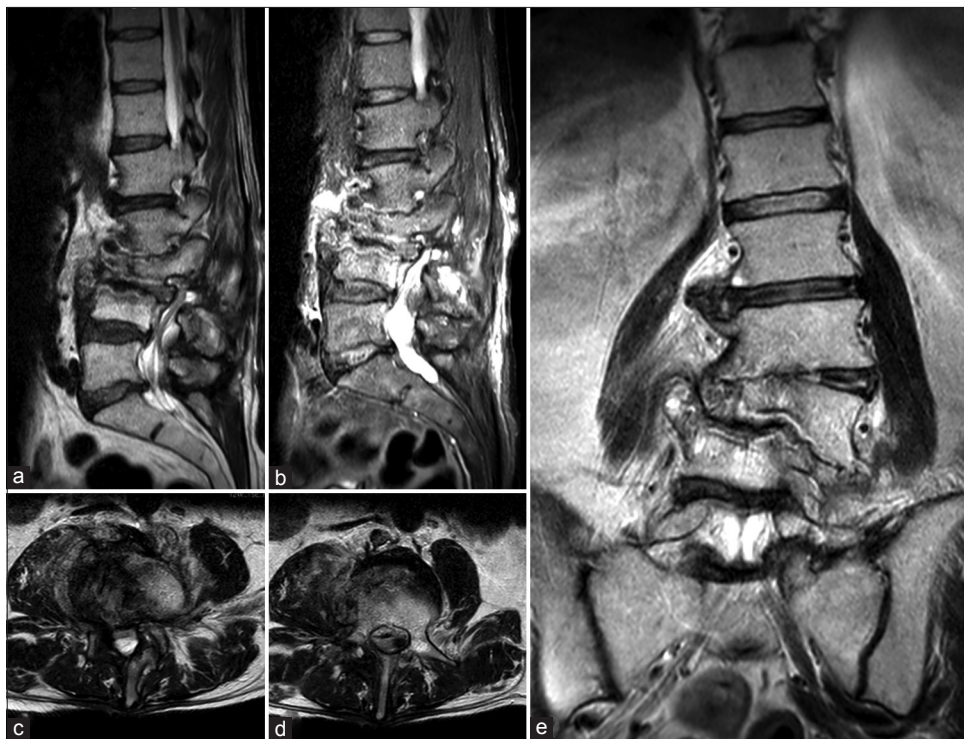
(a) Sagittal T2 and (b) short T1 inversion recovery (STIR)-weighted images showing hyperintensity of L2, L3, and L4 with alteration of vertebral bodies. (c and d) Axial T2-weighted images showing hyperintensity of the right iliopsoas and of the vertebral body of L4. (e) Coronal T2-weighted view showing L3 collapse with complete disruption of L2-L3 and L3-L4 discs.
